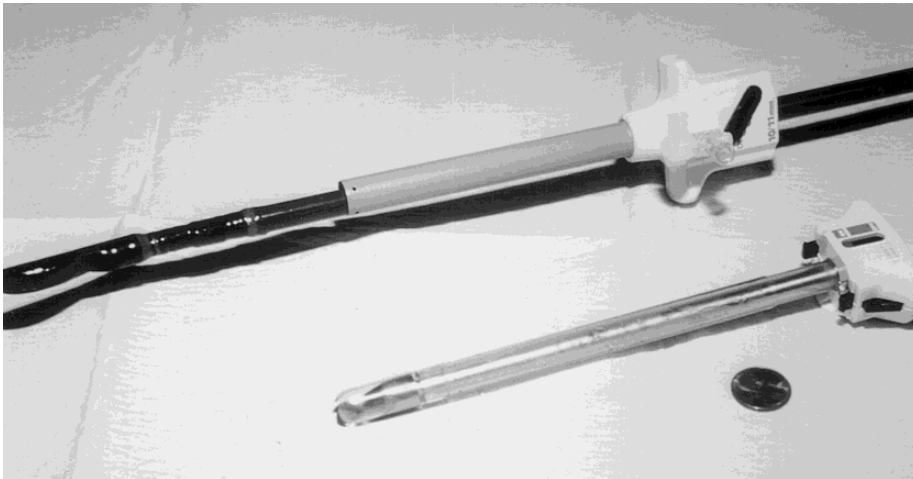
The semiflexible laparoscopic ultrasound probe is easily placed through a 10 mm laparoscopic port. Size is shown in relation to that of a penny (diameter 20 mm.).
